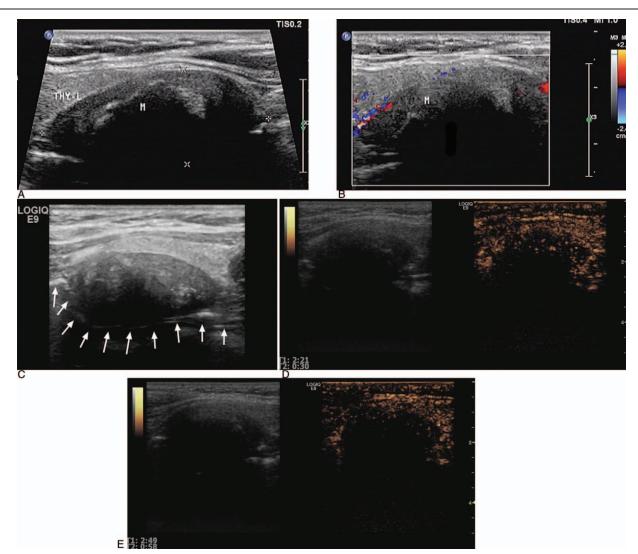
Conventional and contrast enhanced ultrasound of a mass in the neck of a 37-year-old woman. (A) On conventional gray scale ultrasonography, a heterogeneous nodule measuring $36 \times 15 \times 28$ mm with well defined margin was revealed closing to thyroid gland and adjacent to esophagus. The nodule was hypoechoic in the periphery and hyperechoic inside with coarse calcifications and wide posterior shadows. (B) Color Doppler flow imaging demonstrated dotty blood flow signals in the periphery. (C) When the patient was asked to drink water, fluid was observed flowing through the lesion. Air line in the esophagus was marked by arrows. (D) In the arterial phase of contrast enhanced ultrasound, hypoenhancement in the periphery was observed. No enhancement was seen in the center. (E) The lesion was almost non-enhanced in venous phase of contrast enhanced ultrasound.
